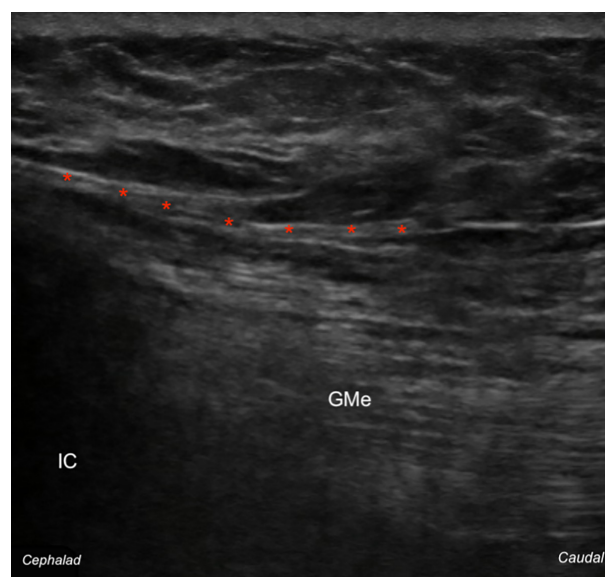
Transverse image at the iliac crest under ultrasound imaging. The red stars indicate the intermediate and lateral branches of the superior cluneal nerve.
